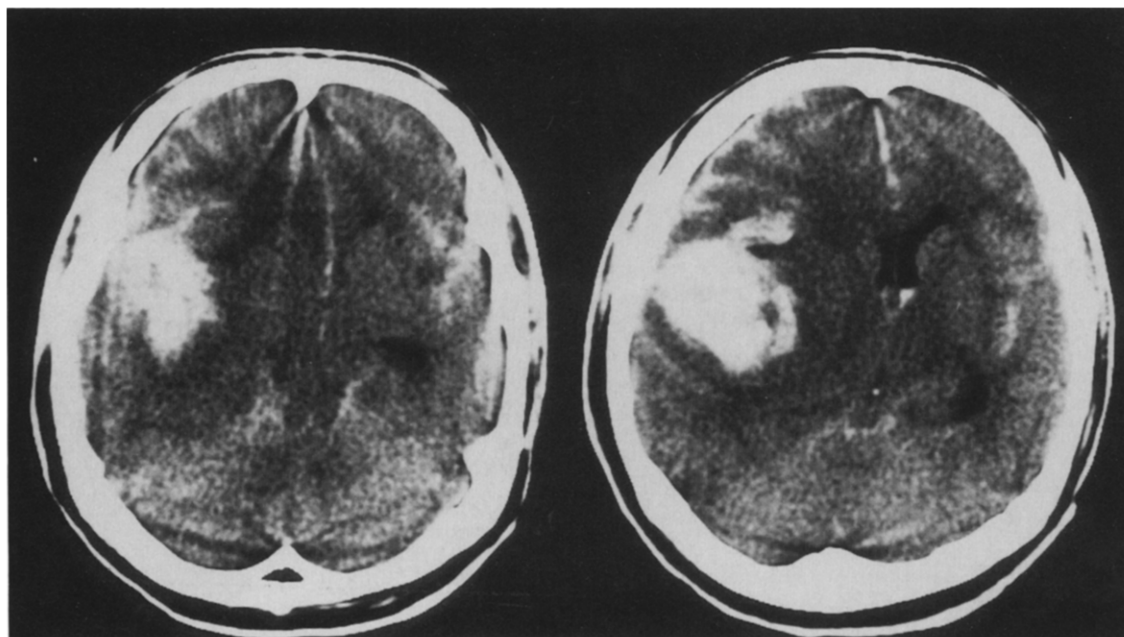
CT scan on arrival revealing a right temporal hematoma and diffuse SAH.
